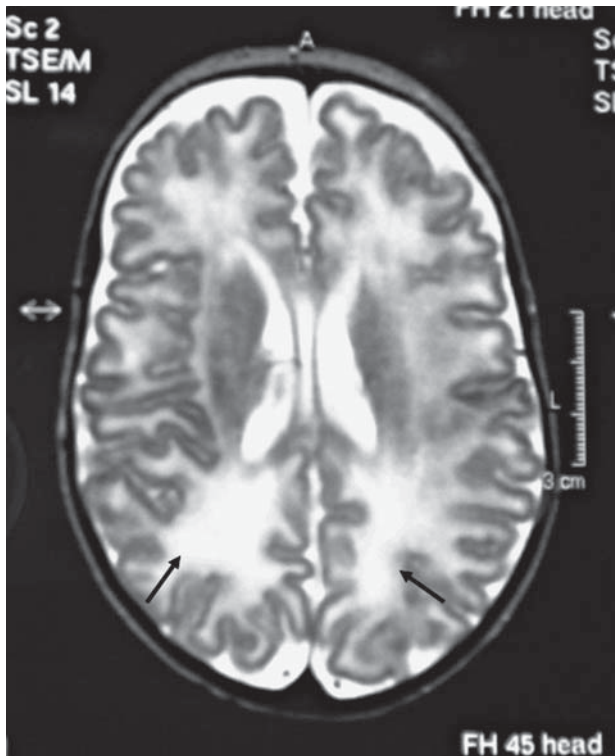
T2-weighted MRI at term equivalent age, axial plane of a preterm infant born at 28 weeks showing (arrows) diffuse high signal intensity (DEHSI) within the periventricular white matter.
